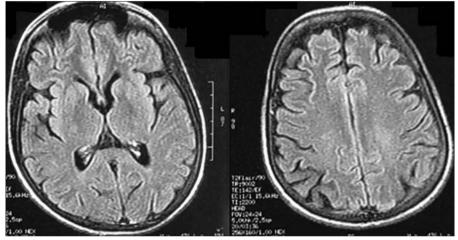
Axial fluid-attenuated inversion recovery (FLAIR) MR images reveal that the lesions have disappeared completely following treatment.
